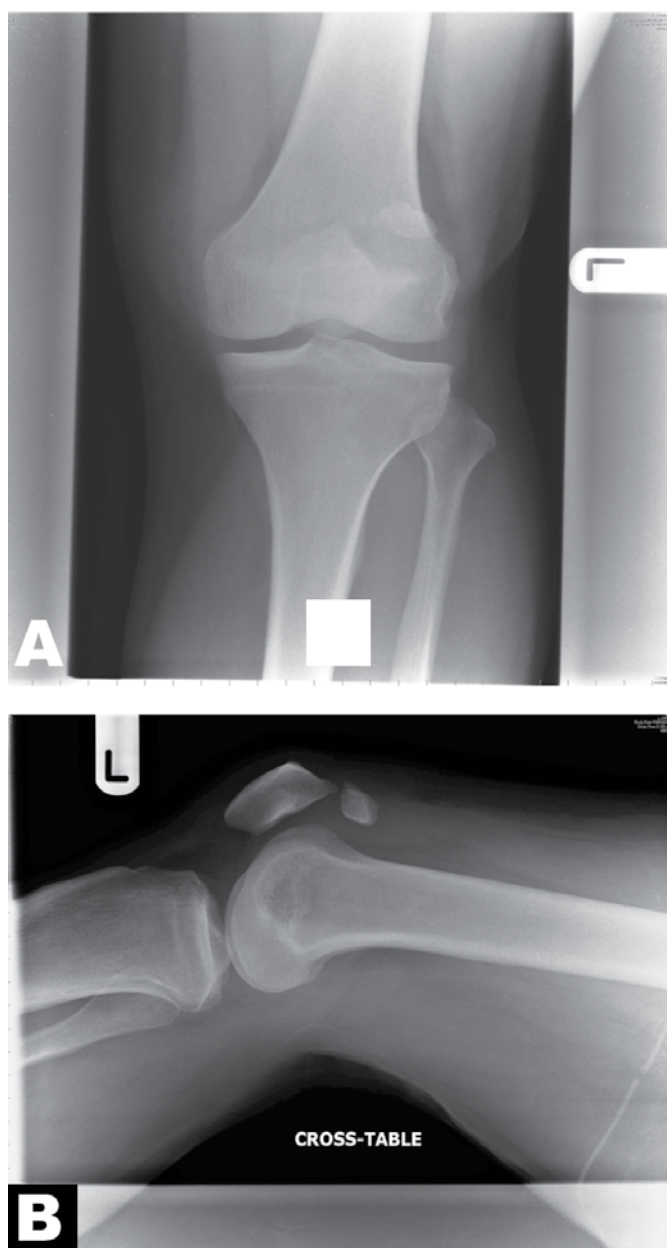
(A) Antero-posterior radiograph of left knee. Indicates superolateral patellar bipartite separation, (B) Lateral radiograph of left knee showing the bipartite separation.
